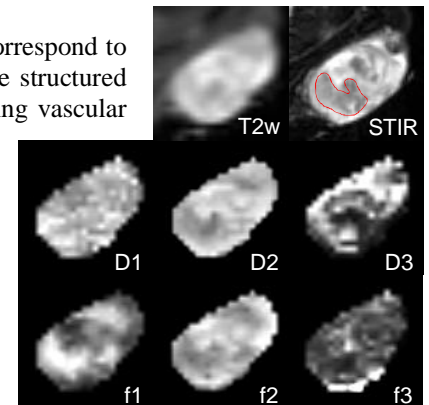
Structures in T2-weighted and STIR images (example ROI in STIR) appear in maps of diffusion parameters (from trace of tensor), particularly in D2, D3, f1, and f2.
